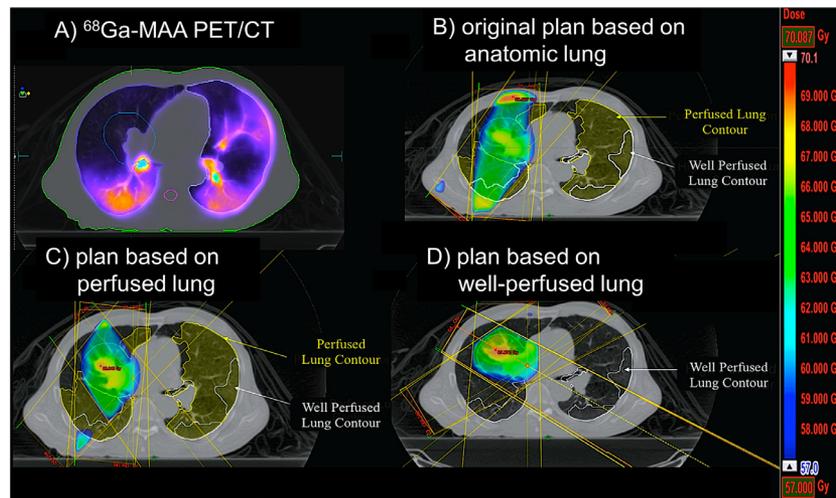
Using ^{68}Ga -MAA Perfusion 4D PET/CT for functionally-adapted radiotherapy planning. (A) Perfusion PET showing the PTV contoured in cyan. (B) The conventional plan based on anatomical lung. (C) Modified plan adapted for “perfused” and (D) “well-perfused” lung contours demonstrating avoidance of contralateral anatomical lung. Adapted with permission from Siva et al.⁴⁰
